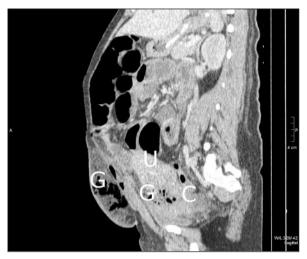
Abdominal CT scan demonstrating gas and pus (G: Gas, U: Uterus, C: Cervics).
